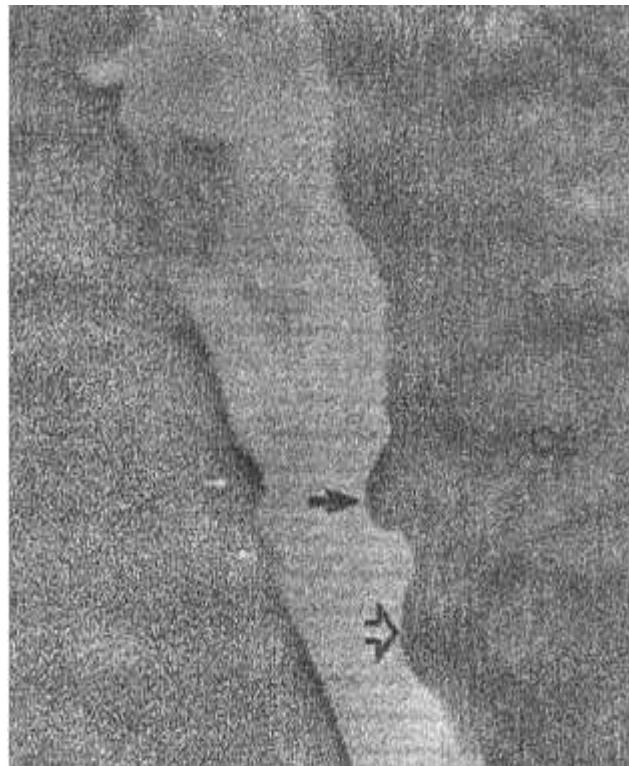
Zenker's diverticulum (A) with corresponding barium x-ray (B).
